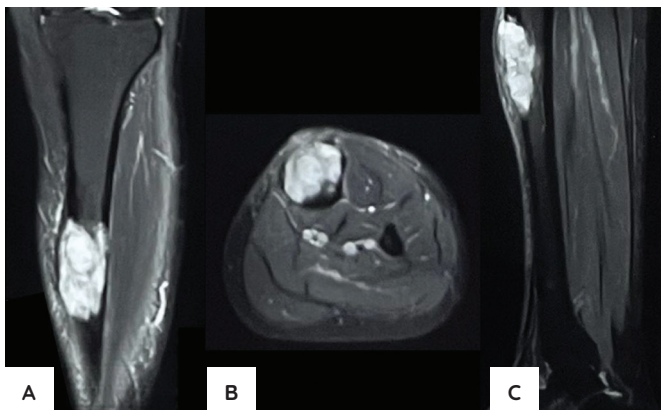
MRI T2 weighted images showing coronal (A), axial (B), and sagittal (C) cuts.
